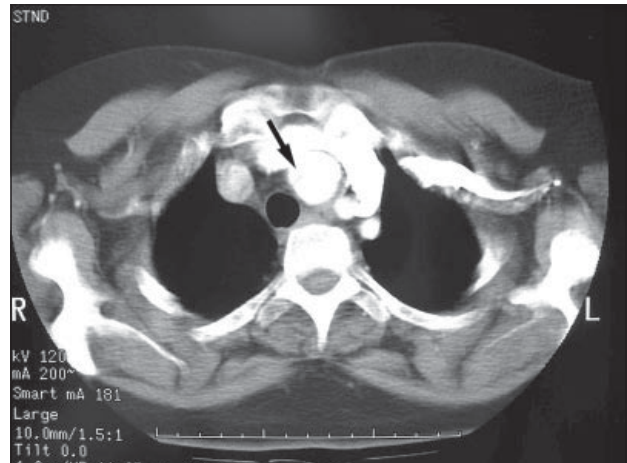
Contrast axial computed tomography of the thorax showing innominate artery aneurysm (arrowhead).
